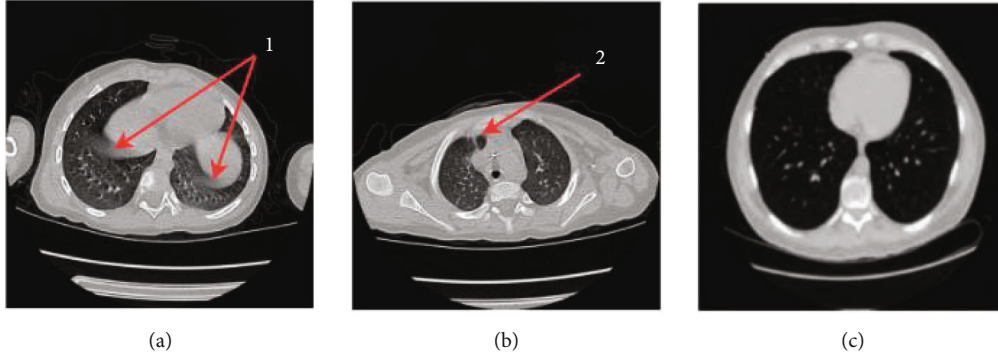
Chest CT image of a preschool child with (a) artifacts (labeled as 1), (b) loss of a local area of the lung (labeled as 2), and (c) adult lungs image which has larger lung area than children).
